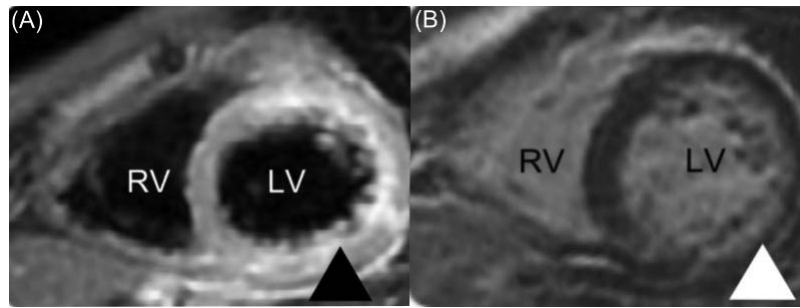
Cardiac magnetic resonance imaging (cMRI) of myocardial edema and injury. (A) The black arrowhead indicates increased myocardial enhancement at the anterior, lateral, and inferior walls of the LV on 2-chamber short-axis view. (B) The white arrowhead shows the delayed gadolinium enhancement of the lateral wall of LV at the follow-up cMRI in 10 months. LV: left ventricle; RV: right ventricle.
